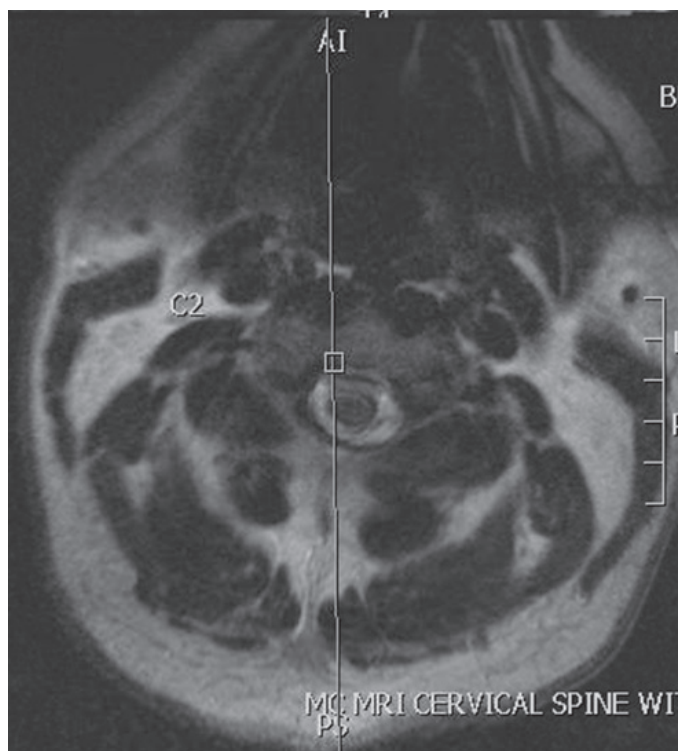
Post-surgery axial cut MRI C-spine. The arrows point to the spinal hematoma pre-evacuation.
